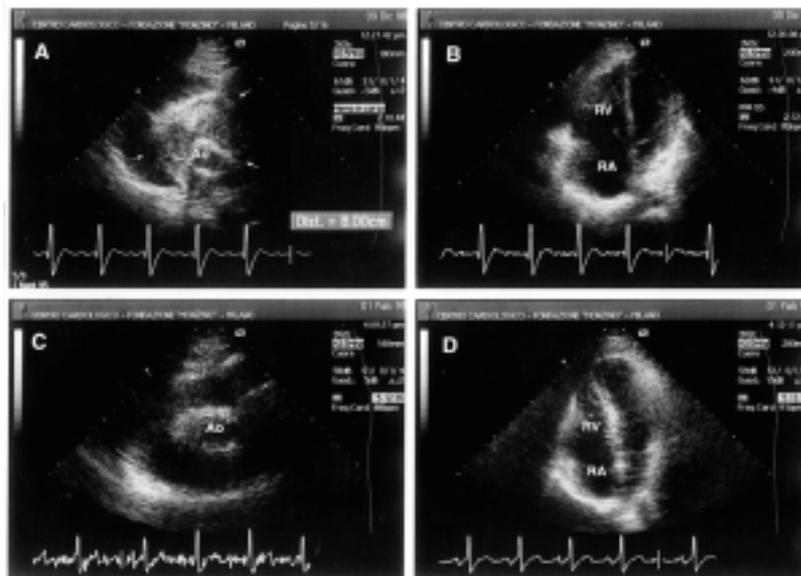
A: the preoperative parasternal short-axis view demonstrates, around the aortic root (Ao), the pseudoaneurysm with a diameter of 8 cm and irregular echodensity within the lumen. B: the preoperative apical 4-axis view shows right ventricular (RV) and right atrial (RA) enlargement. C: at the postoperative short-axis view of the ascending aorta (Ao) there is no redundant tissue around the Ao and it may be seen that the pulmonary artery is normal in size. D: the late postoperative 4-axis view shows normal RV and RA dimensions.
